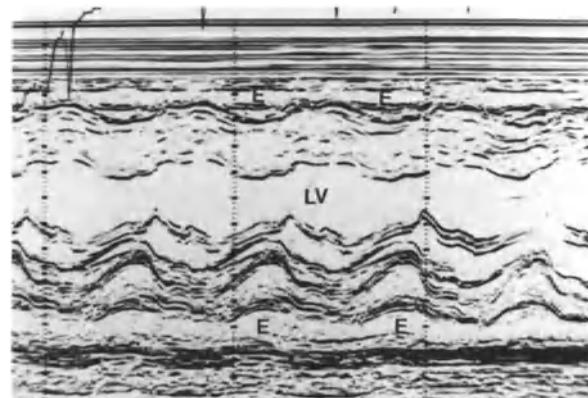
M-Mode echocardiogram showing echo-free areas anterior and posterior to the left ventricle due to a large pericardial effusion (E).
